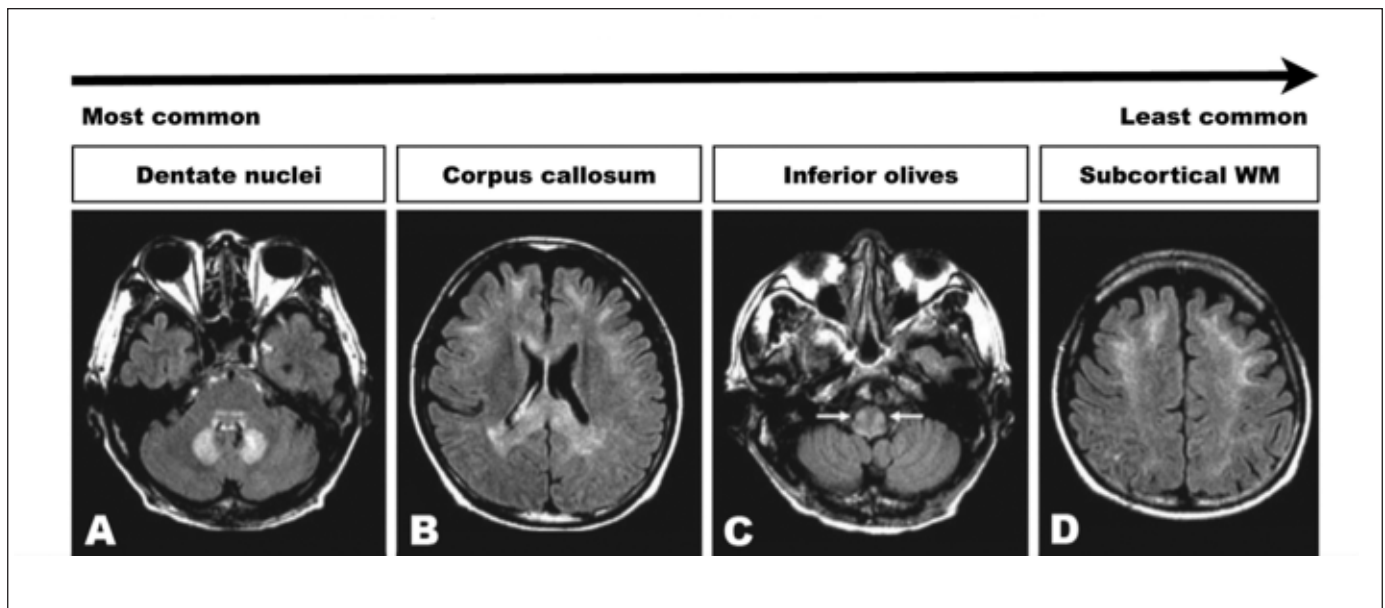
Summary of metronidazole-induced MRI features from most common (left, A) to least common (right, D). Metronidazole-induced MRI FLAIR hyperintensities are found within the cerebellar dentate nuclei (A), corpus callosum (splenium) (B), inferior olives (C) and subcortical white matter (WD) (D). (Adapted from Kim et al. (40) with permission).
